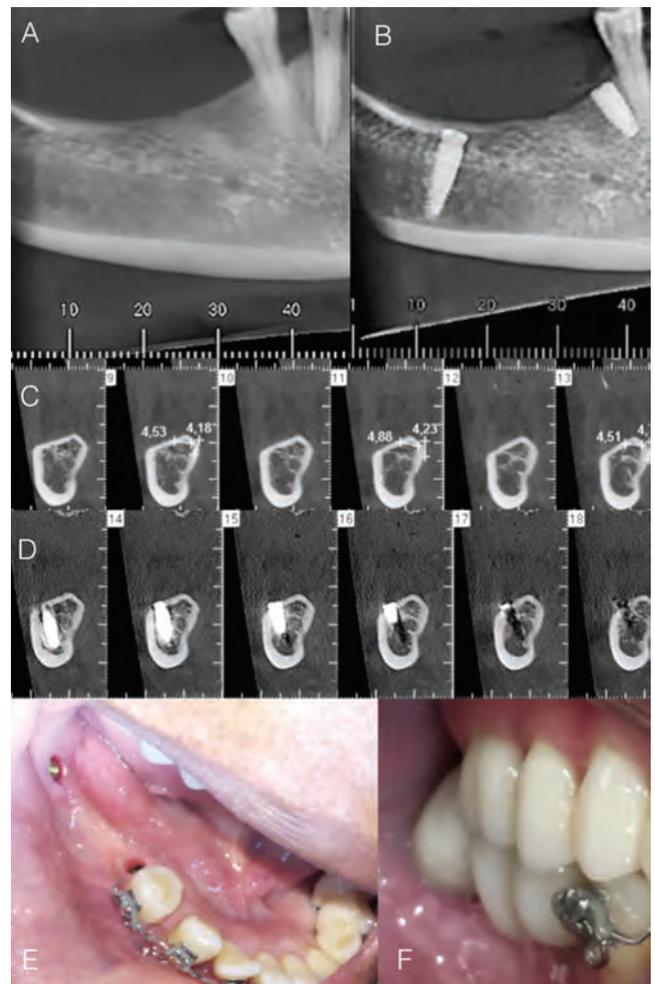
[A] Pre and [B] postoperative panoramic view; [C] Pre and [D] postoperative transaxial CBCT of the MPR; [E] Clinical view of the Implants 31 and 29; [F] FPR in good relationship with their antagonists.
